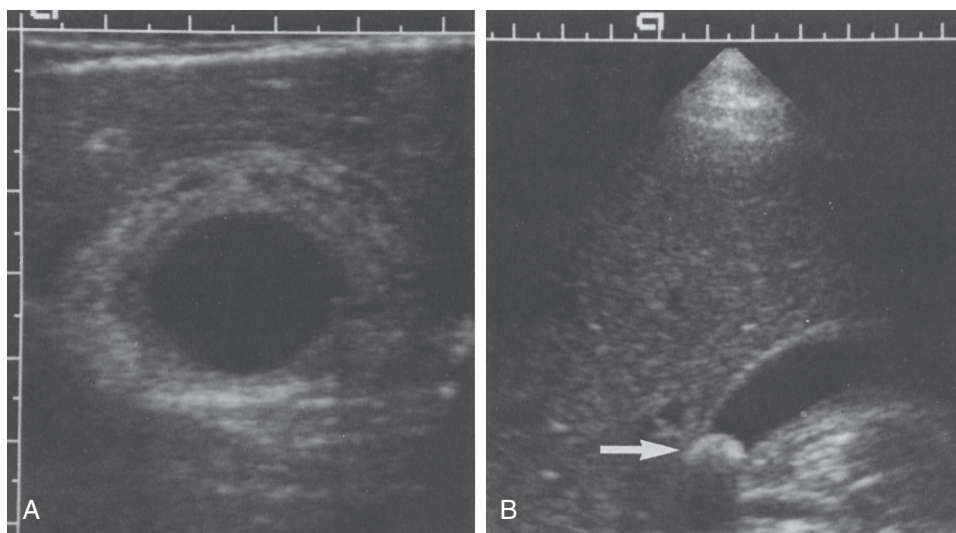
Transverse scan with linear array transducer shows pericholic edema in a teenaged boy, who presented with severe pain in the right upper quadrant from acute cholecystitis (A). A longitudinal scan of the right upper quadrant (B) shows a stone (arrow) that was thought to be impacted in the neck of the gallbladder because it did not change at all with position. The patient had severe pain with palpation over the gallbladder. (From Teele R, Share J. The liver. In: *Ultrasonography of Infants and Children*. Philadelphia: WB Saunders; 1991.)
